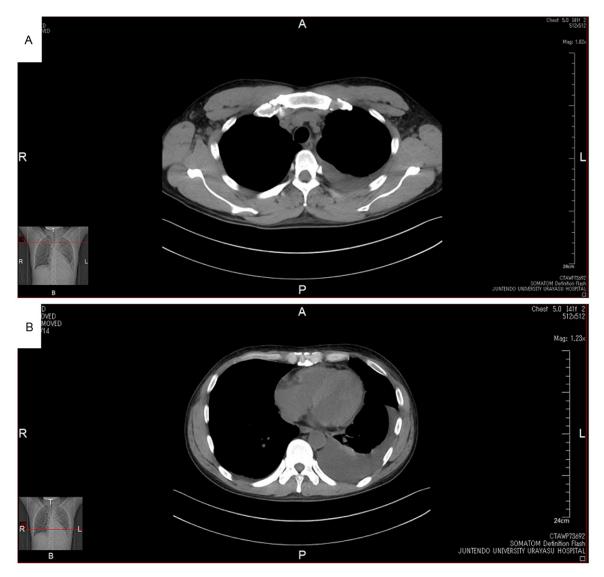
A, B. Chest CT revealed left-dominant bilateral pleural effusion, but no thymoma.
